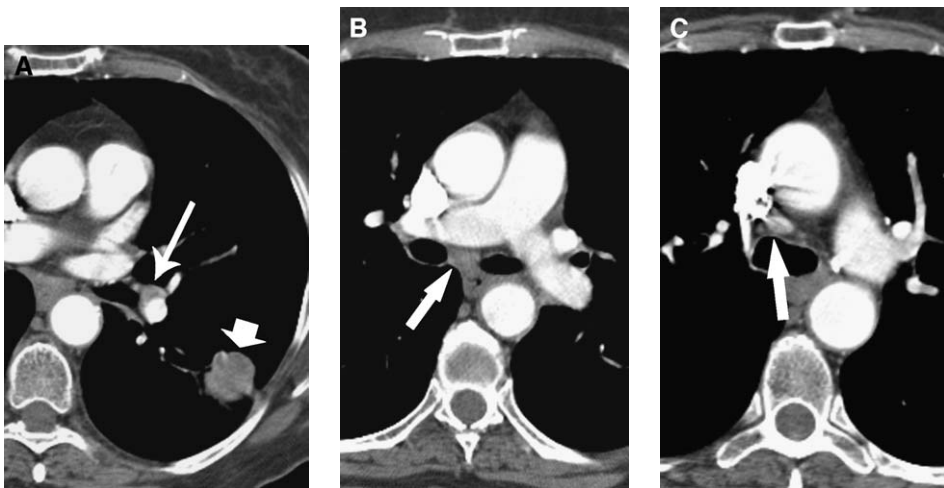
A 73-year-old woman with non-small cell lung cancer of the left lower lobe and N1, N2, and N3 disease. (A) Axial image from a contrast-enhanced CT scan reveals a left lower lobe mass (*short arrow*) and ipsilateral hilar adenopathy (*long arrow*) indicating N1 disease. (B) Image more cephalad reveals subcarinal adenopathy (*arrow*) indicating N2 disease. (C) More superiorly, an image demonstrates right lower paratracheal adenopathy (*arrow*) consistent with N3 disease.
